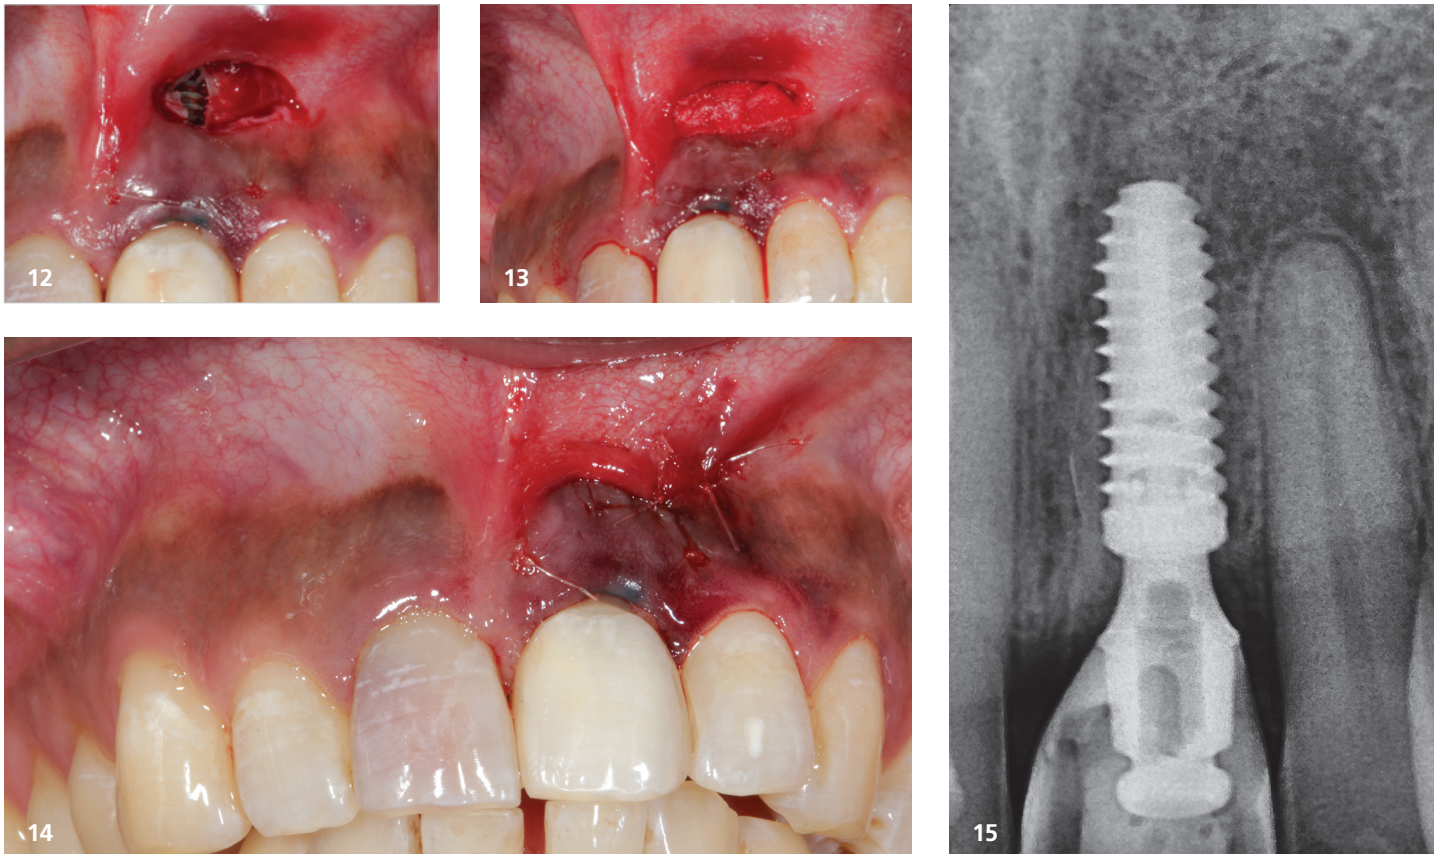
Fenestration exposed with semilunar incision. Fig. 13: Guided bone regeneration done with bone grafting material and a membrane. Fig. 14: Tension-free closure. Fig. 15: Immediate post-op radiograph after seating of the provisional crowns.
